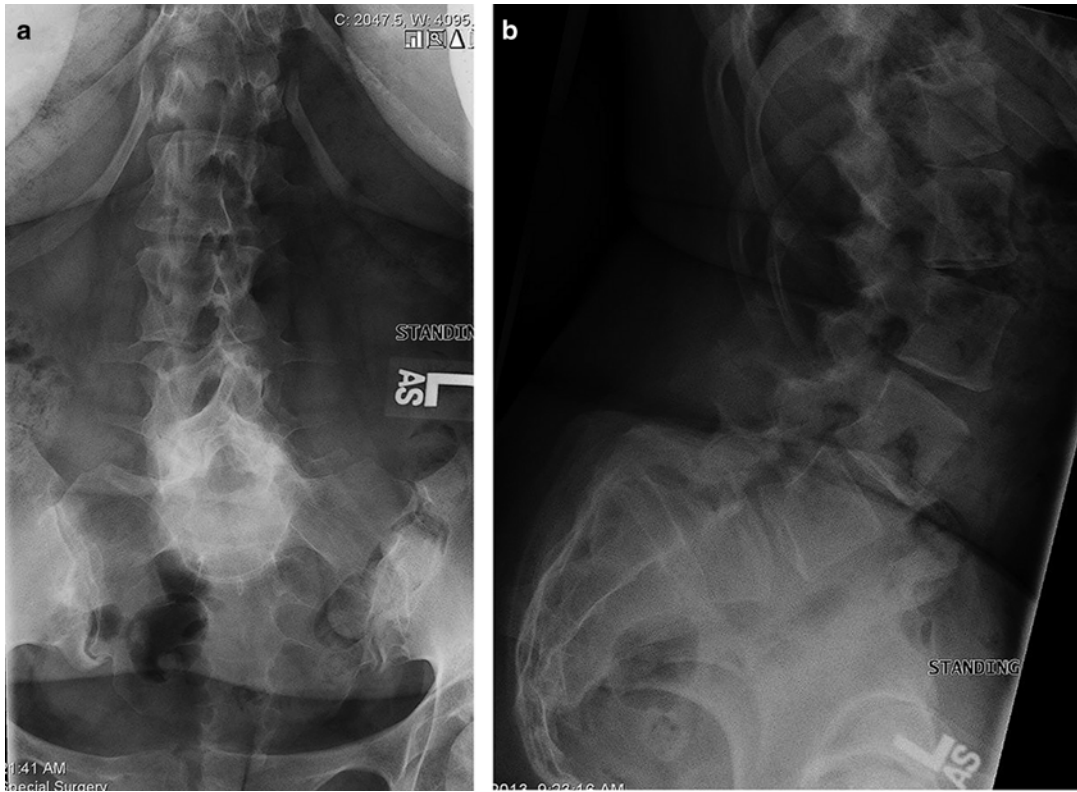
(a, b) Case 1: AP and lateral X-ray views in a patient with advanced spondyloptosis
